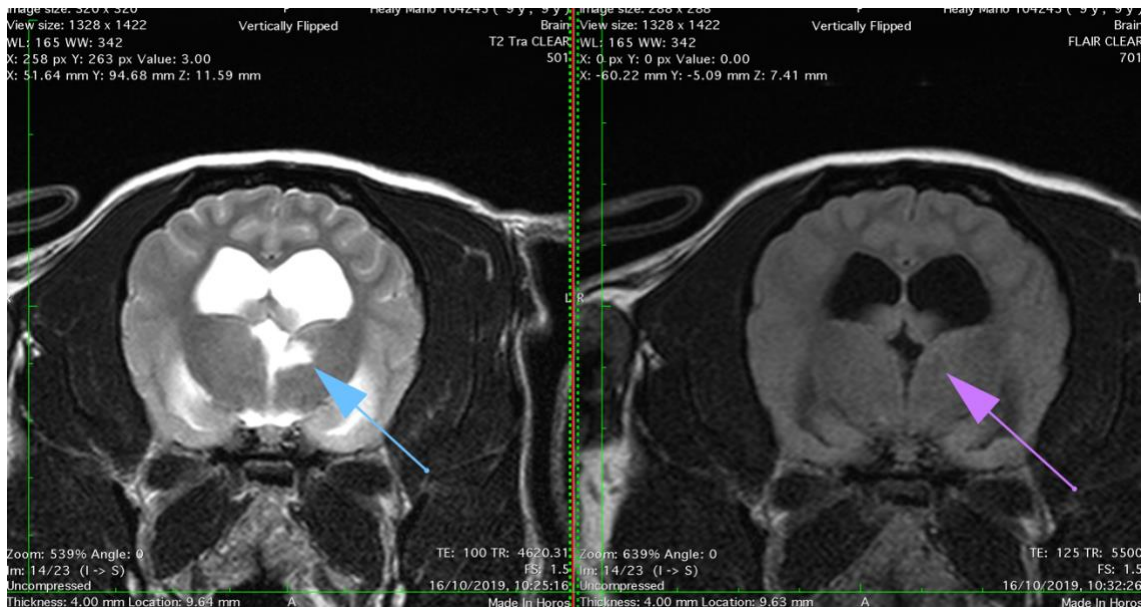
Trv T2W (left) and FLAIR (right) caudal thalamus
